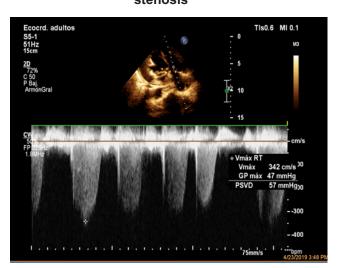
The axis of 4 cameras from the apex of the Doppler echocardiogram. An elevation of pressures is observed in the right ventricle that infers severe pulmonary hypertension: Maximum pressure gradient of 47 mmHg and Systolic pressure of the Right Ventricle of 57 mm Hg
